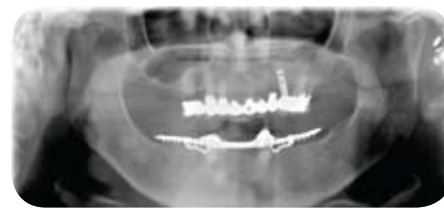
Panoramic radiograph shows a suspicious area around the root of No. 6. Observe extensive decay, bone loss and a failing dental implant.
